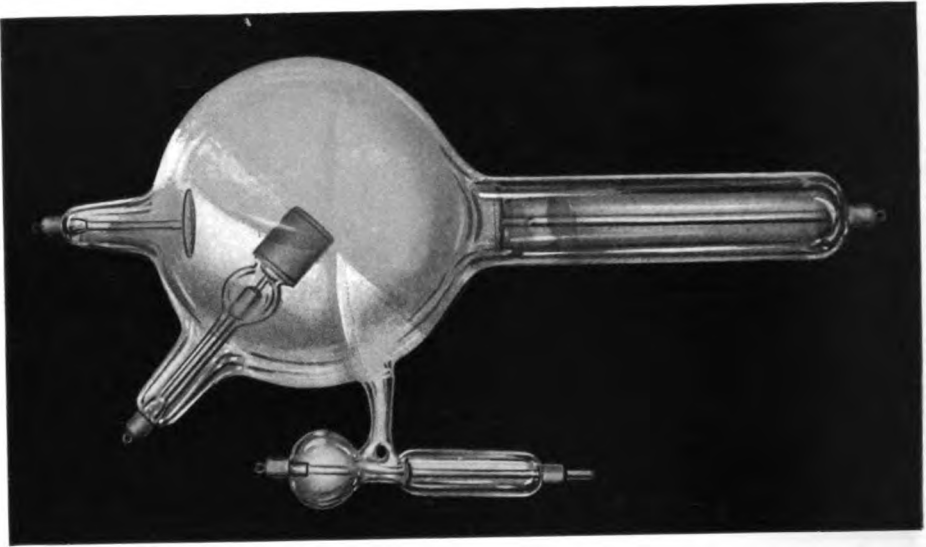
X-ray tube in operation. Too high a degree of vacuum.
